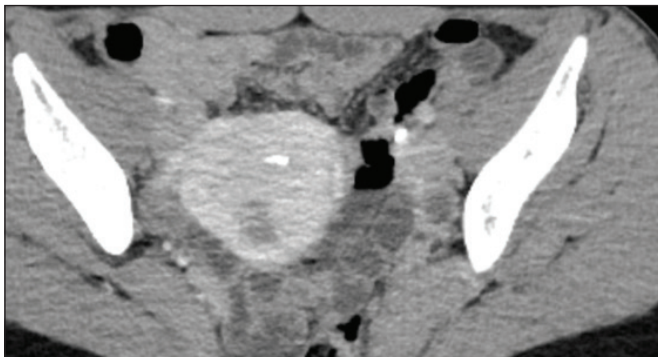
CT venograms at 6-month follow-up showing successful embolization of the left ovarian vein and no filling of the previously seen large left pelvic varicosities. Symptoms resolved and the patient reported that she “felt great.”
